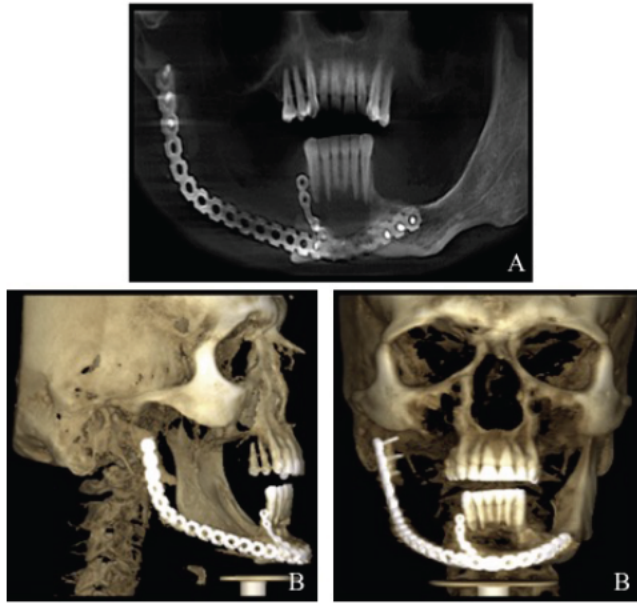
A, reformat panoramic .B, three-dimensional view. CBCT shows segmental mandibulectomy and the reconstruction plate.
